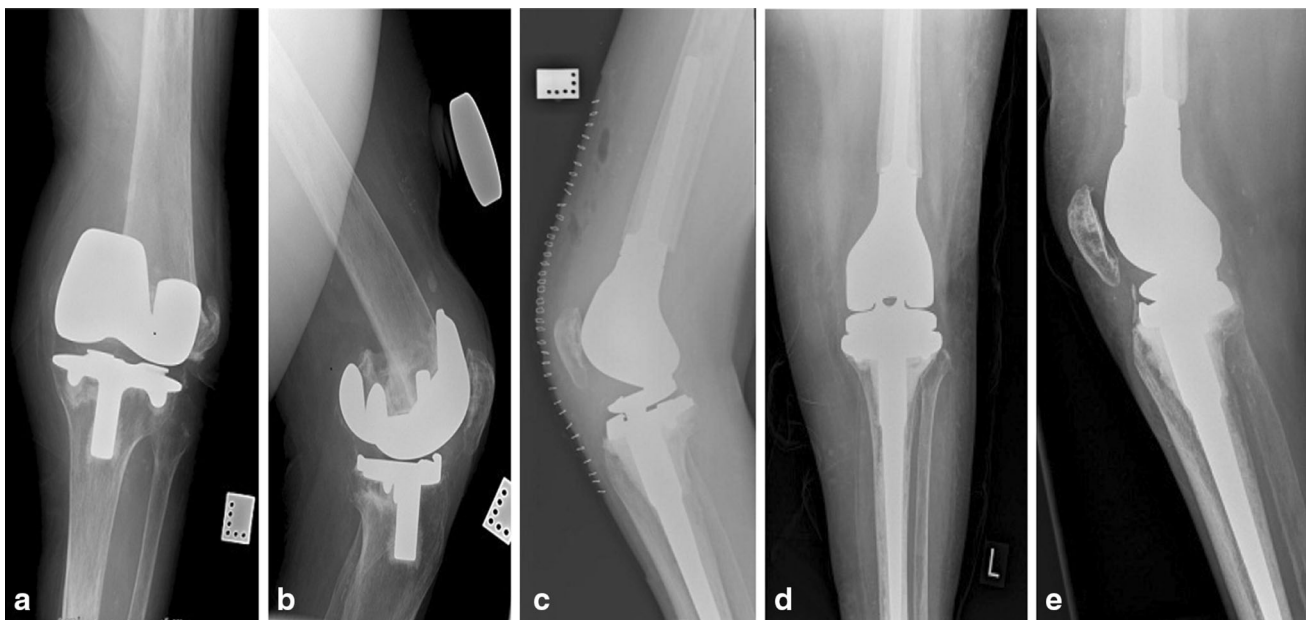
Antero-posterior (a) and lateral (b) radiographs of periprosthetic fracture with loose prosthesis in a rheumatoid patient. Post-operative lateral radiograph (c). Antero-posterior (d) and lateral (e) radiographs at 18 months post-operatively with no signs of loosening
